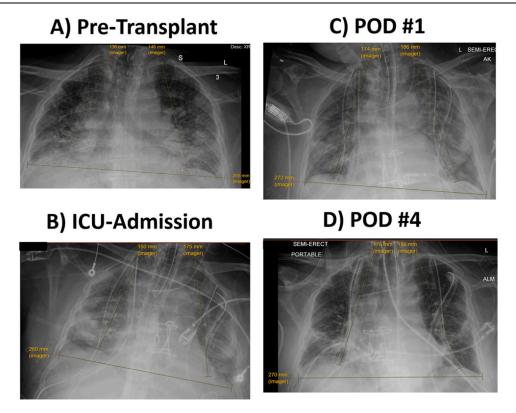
Serial chest X-rays at defined time points. Right lung left lung and diaphragm measurements as indicated. ICU, intensive care unit; mm, millimeter; POD, postoperative day.
